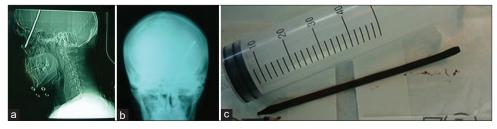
(a) A skull X-ray (lateral view) reveals the presence of a rifle rod. (b) A skull X-ray (posteroanterior view) shows the penetrating rifle rod. (c) The extracted object (rifle rod).
